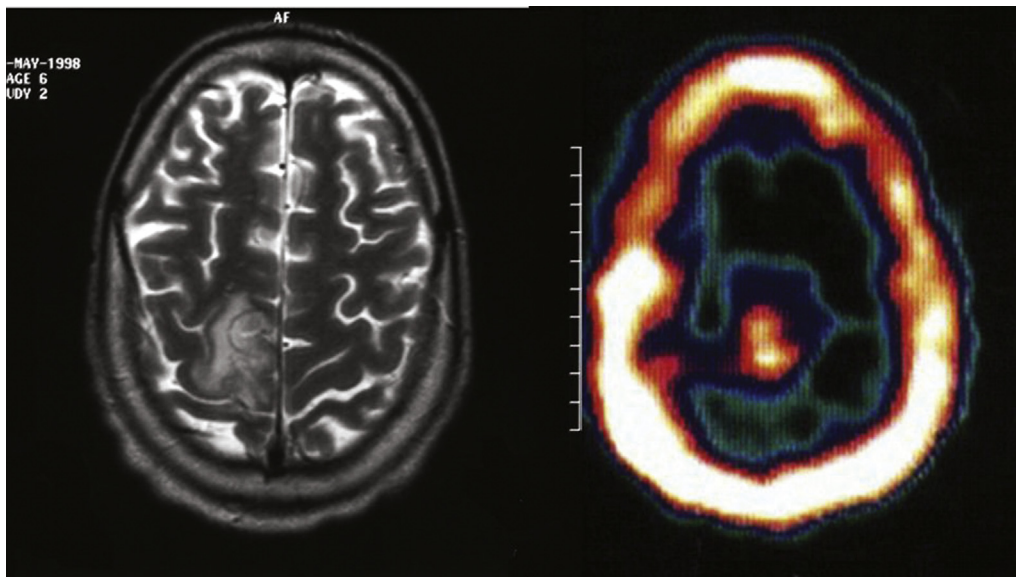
Paired MRI and FDG-PET scans of a patient with AIDS-related PCL.
